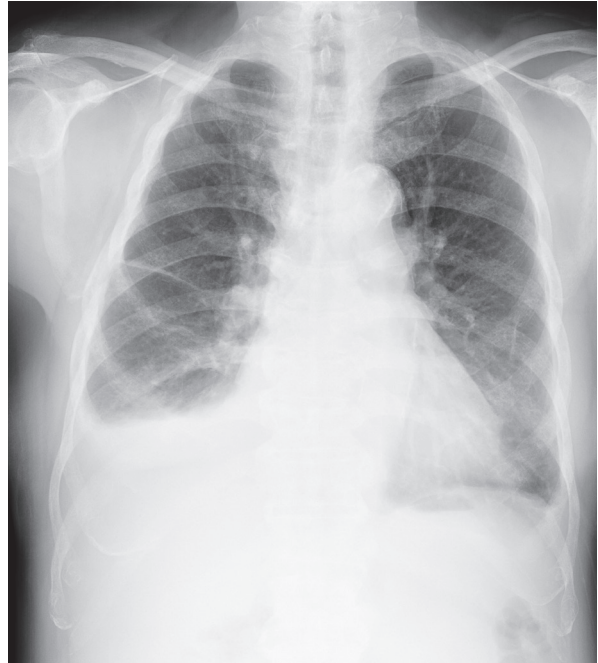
Chest radiograph showed bilateral blunting of the costophrenic angle and lower lung patchy infiltrates.
